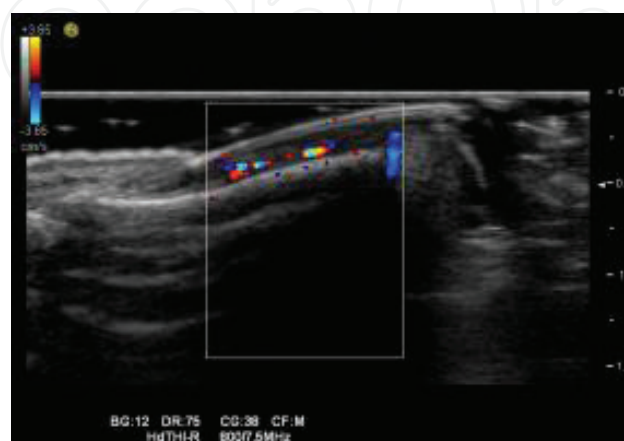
Ultrasonographic image of the healthy nail. Nail sonogram (18 MHz), showing the superficial hyperechogenic NP and the underlying hypoechoic NB containing blood vessels.
